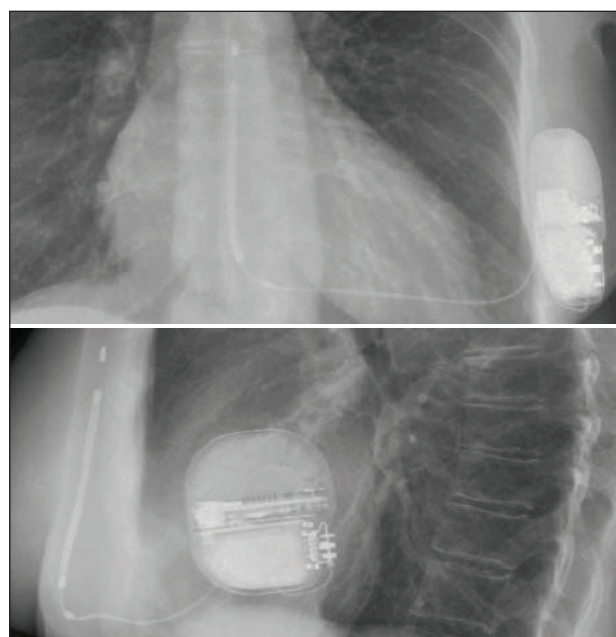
Post-implant radiography demonstrating optimal placement of the pulse generator and subcutaneous lead⁴².
